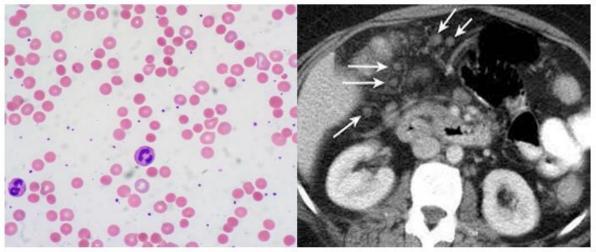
Peripheral blood film showing spherocytes, polychromatic cells and CT abdomen showing multiple enlarged intra-abdominal lymph nodes respectively.
